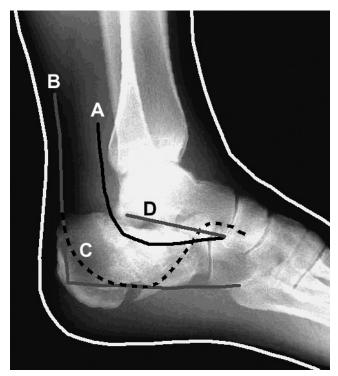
Radiograph of hindfoot demonstrating placement of incisions on the lateral foot for operative repair of calcaneal fractures. (A) Direct lateral approach. (B) Extended lateral approach. (C) Smile approach. (D) Sinus tarsi approach.
